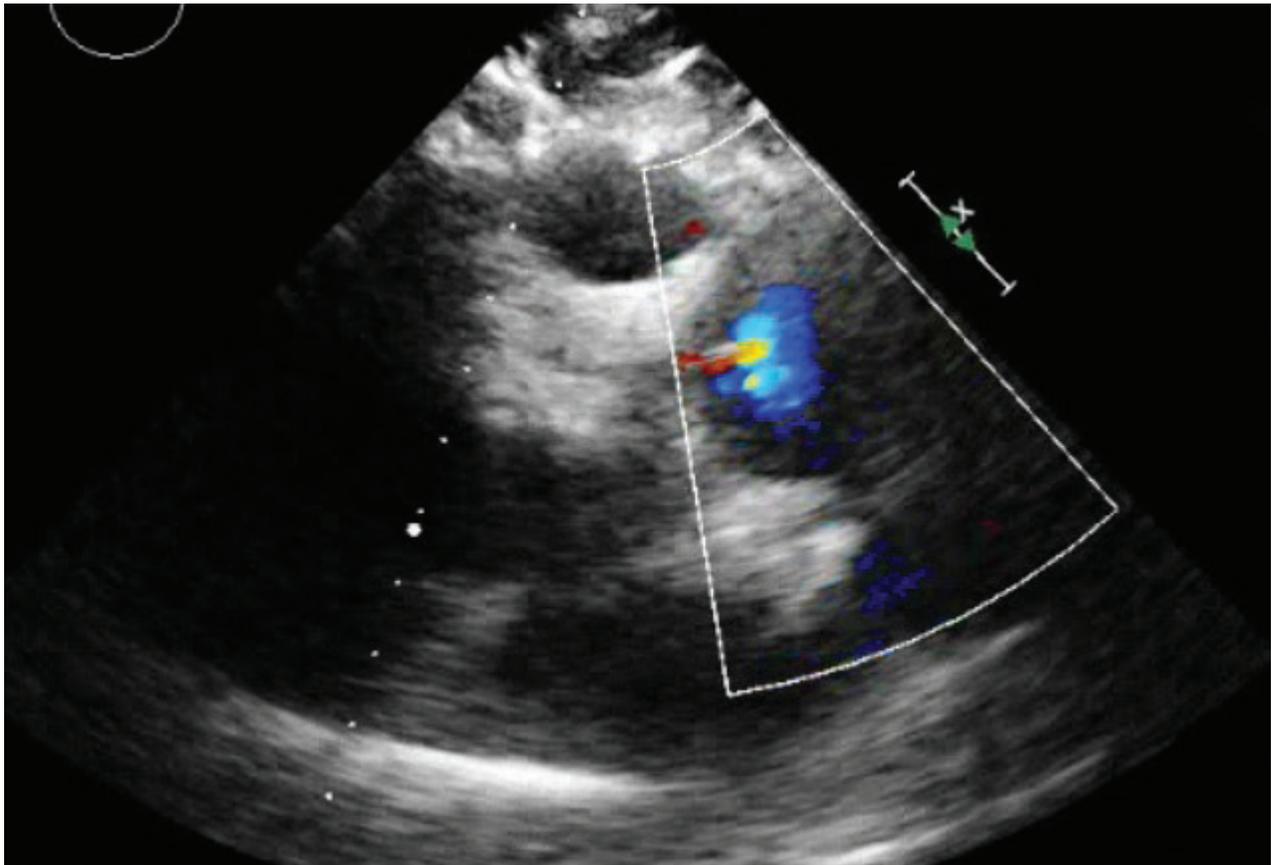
High-parasternal-short-axis view showing turbulence in the RV-PA conduit. Conduits such as these are often difficult to visualize by echocardiography due to anatomical position, body habitus, or surgical scarring.
